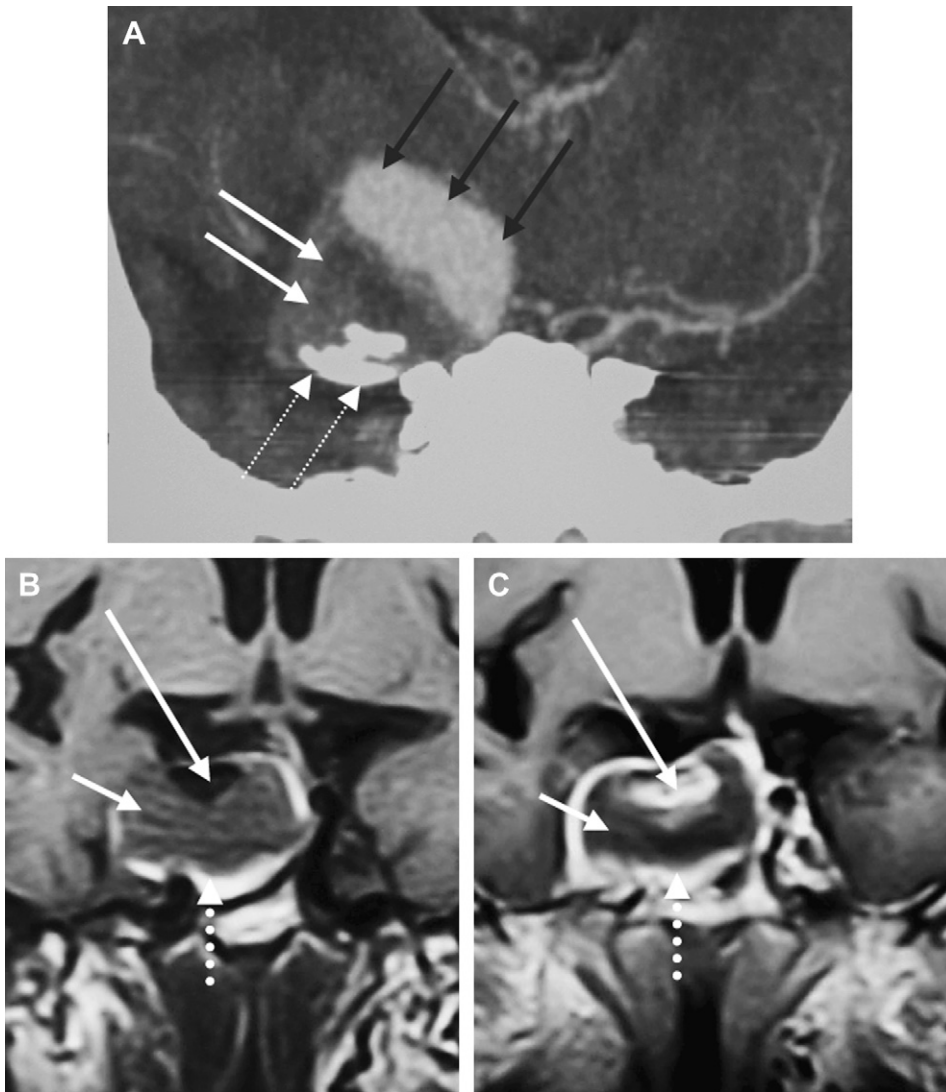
Coronal CT reconstruction from a CT angiogram (A) demonstrates a giant cavernous carotid aneurysm shown as a complex lesion in the right cavernous sinus and supraclinoid region, with an area of early enhancement which corresponds to the patent lumen (*black arrows*) and a non-enhancing hypodense area suggesting thrombus (*white arrows*). Also noted are extensive, layered atheromatous calcifications (*white dashed arrows*). Coronal pre-gadolinium (B) and post-gadolinium (C) T1W MR images (on another patient) show a complex lesion in the right cavernous sinus at the expected location of the cavernous carotid artery. The lesion has an eccentric flow void enhancing after gadolinium, corresponding to the patent arterial lumen (*long white arrows in C–D*), hypointense material consistent with early clot (*short white arrows*) and, at the periphery, spontaneous T1 hyperintensity, suggesting the presence of metahemoglobin (*white dashed arrows*). (Cavernous carotid artery aneurysm).
